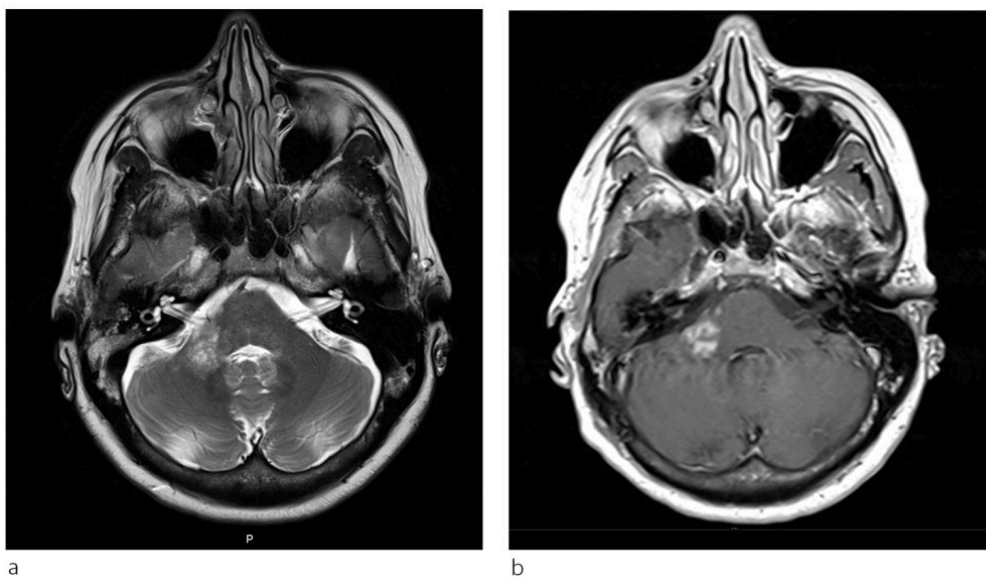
a) The T2-weighted image shows an inhomogeneous hyperintense lesion in the right cerebellar peduncle that cannot easily be distinguished from a multiple sclerosis-associated lesion. b)
